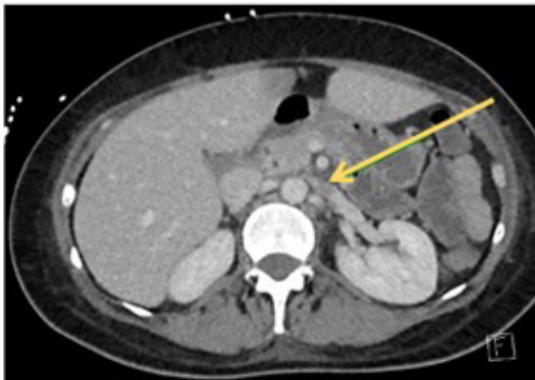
Axial CT with contrast, demonstrating extension of thrombus into left renal vein.
